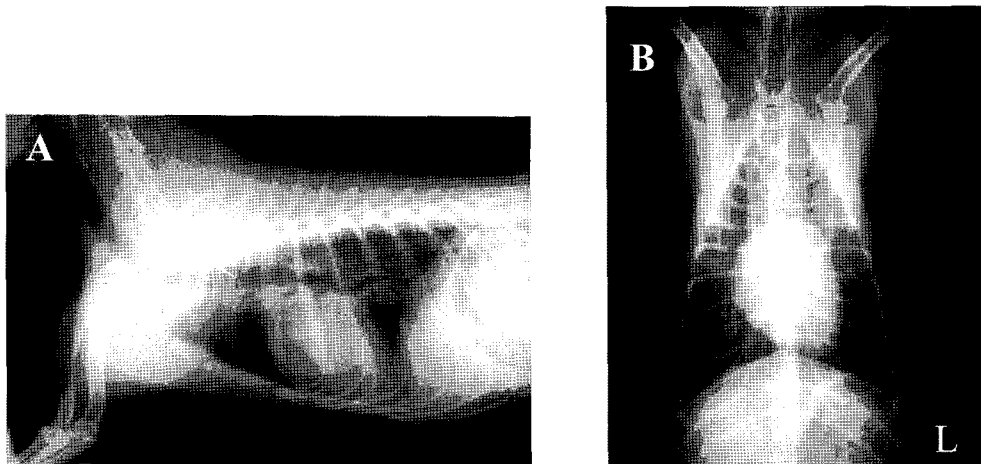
Lateral (A) and ventrodorsal (B) views of thoracic radiography. There are two fishhooks in the thoracic esophagus and cardia region.
